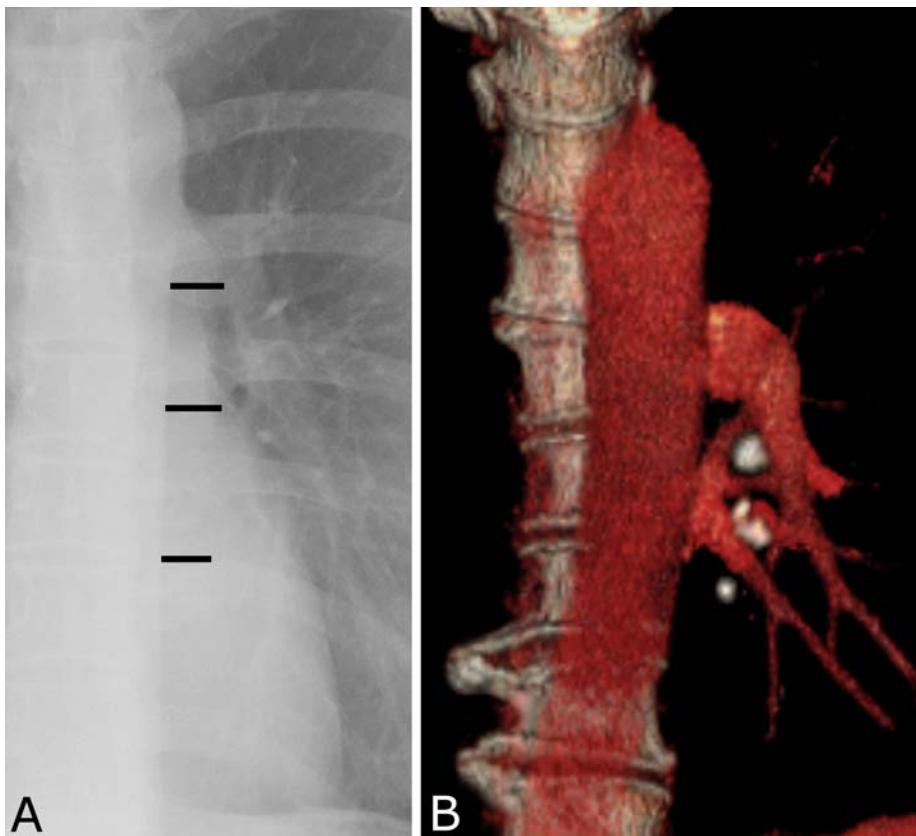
Descending aorta. A. Frontal radiograph shows that the descending aorta is well seen (because it is bordered by air) even though it is posterior to the heart. B. Volume rendered CT scan shows the descending aorta coursing posteriorly along the spine.
